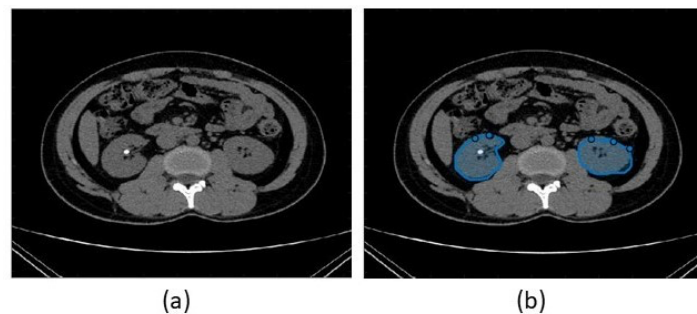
(a)Input CT image (b) grayscale image with kidneys highlighted
